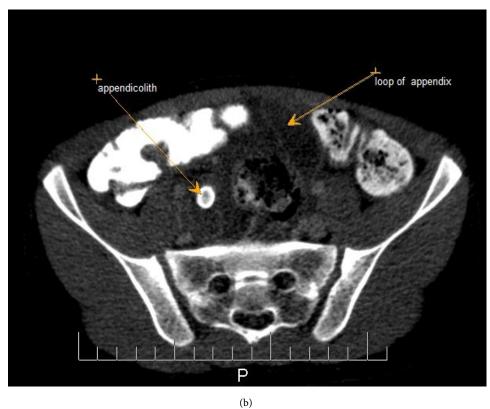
(a) Axial contrast enhanced CT scan demonestrates large appendix 22 mm in diameter with wall enhancement and an appendicolith; (b) Axial contrast enhanced CT scan at the level of sacroiliac joints demonestrates elongation of appedix to left side and another appendicolith, which is 14 mm in size.
